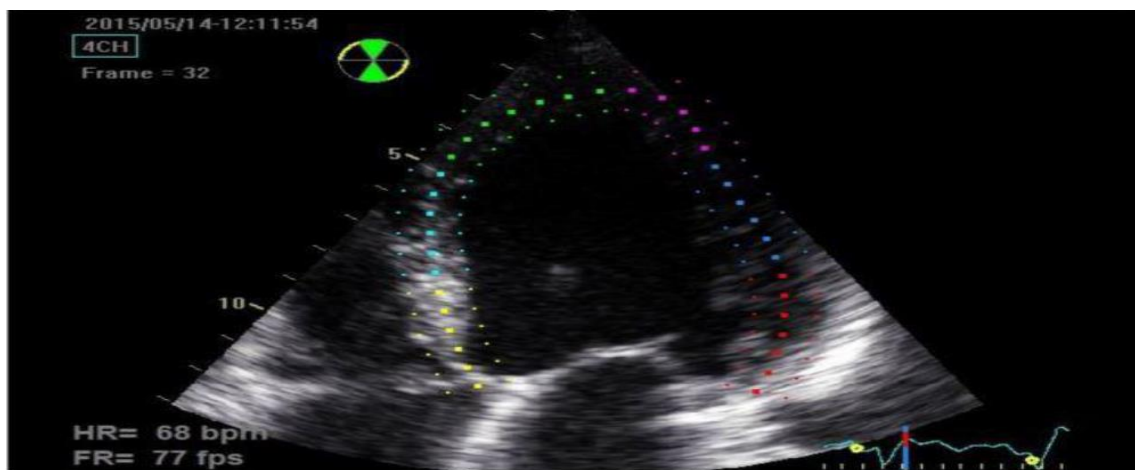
Apical four chamber (A4C) view demonstrating endocardial border of LV by STE (Semi automated tracing)
